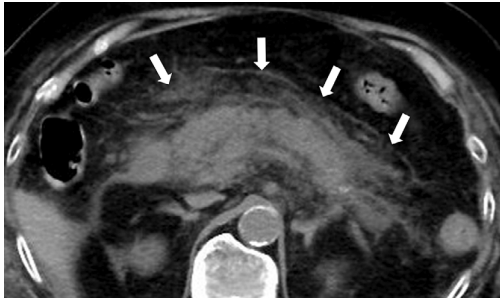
Abdominal computed tomography showed the diffuse enlargement of the pancreatic parenchyma with surrounding fluid collection (arrows).
